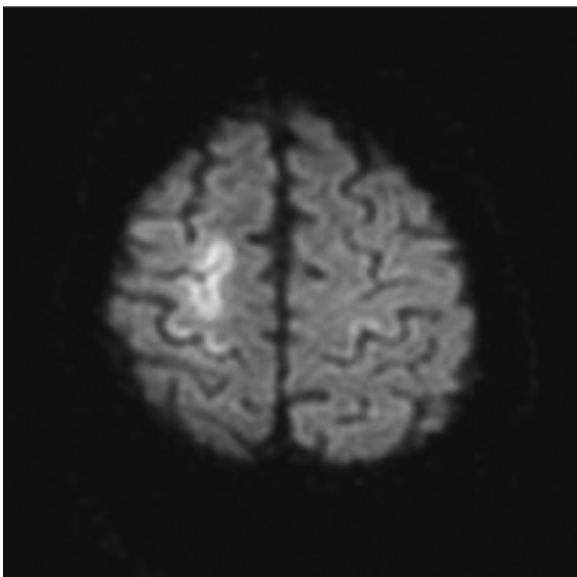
Brain MRI performed 72 h after the onset of symptoms. Diffusion weighted imaging: cortical areas with restricted diffusion and serpiginous shape, suggestive of recent venous stroke.
